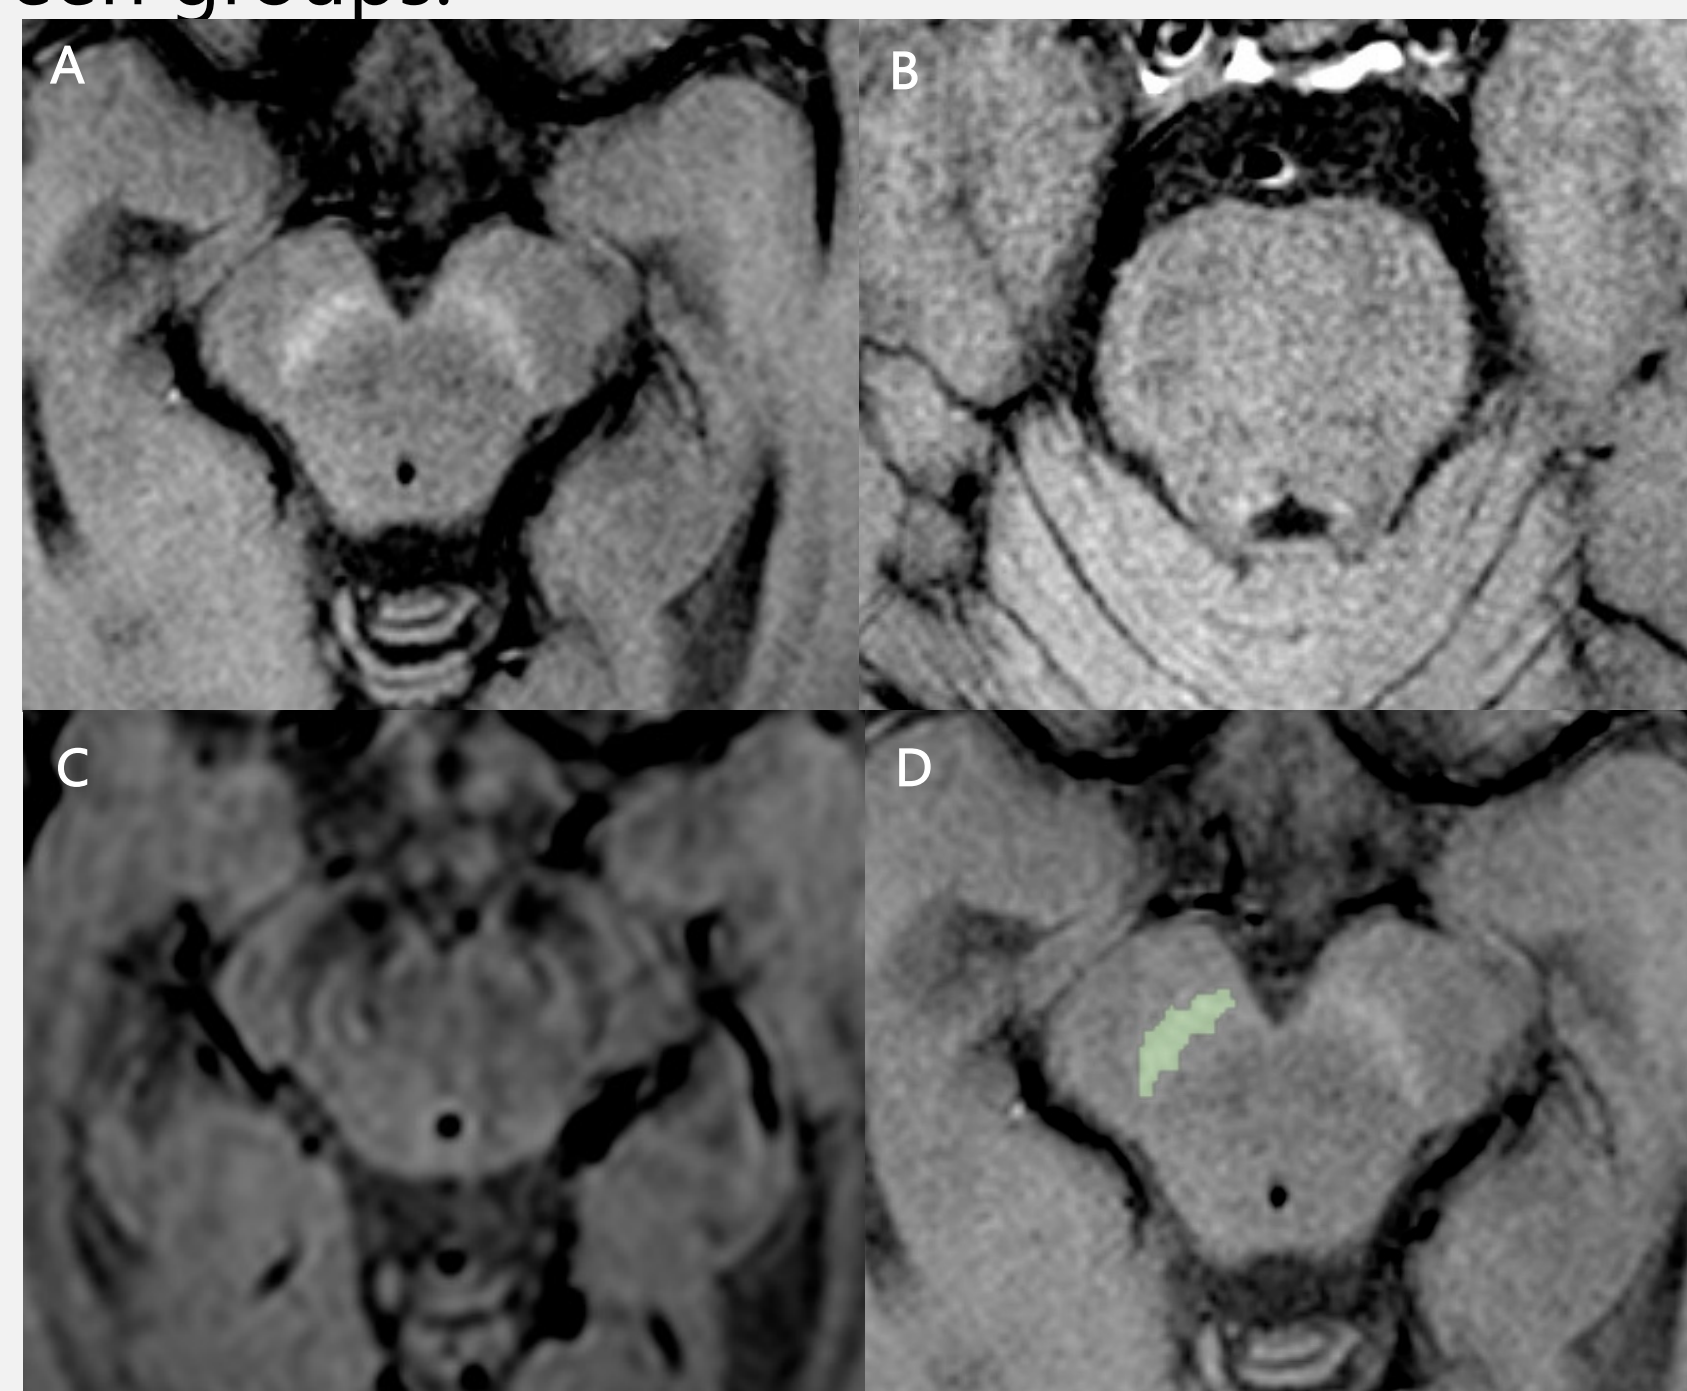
NM-MRI images at the level of the SN (A) and at the level of the LC (B), showing normal NM area and signal intensity. SWI image (C) at the level of the SN, showing normal bilateral N-1 hyperintensity. NM-MRI with semi-automatic segmentation of the SN is shown in D. All imaging data were acquired using a 3.0 Tesla Philips Achieva MR scanner.
